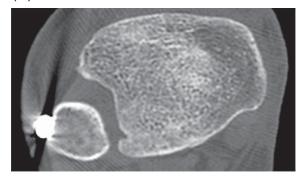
Preoperative CT scan showing malreduced syndesmosis
